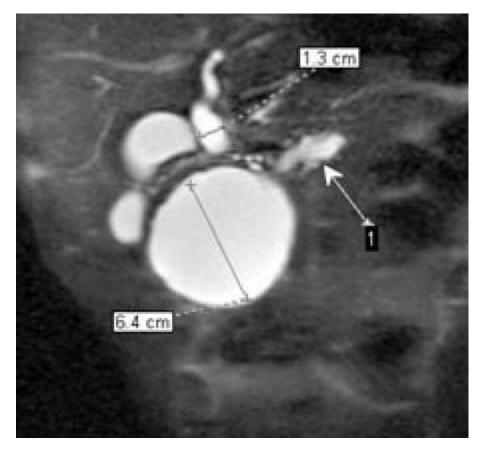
MRI of patient P., 40 years old, with an attack of acute pancreatitis in history: a - T2-WI in the coronal plane, 1 — pseudocyst pancreatic head with a formed wall, 2 — I portion of the duodenum, 3 — down leg duodenum; *b*, *c*, *d* — T2-WI in the axial plane at different levels, pseudocyst occupies the entire head of the pancreas and compresses MPD at this level, MPD in the body and tail expanded to 0.9 cm, crimped, side ducts cystic dilated, twisted, e - T1-WI FS in the axial plane, with normal parenchyma anteroposterior size of the body and tail of the pancreas atrophied, its volume is reduced; *f* — MR-cholangiography, 1 — extended MPD above the obstruction, pseudocyst large (6.4 cm) deforms the duodenum, squeezes her I portion, CBD is extended to 1.3 cm and its pancreatic department is not visualized.
